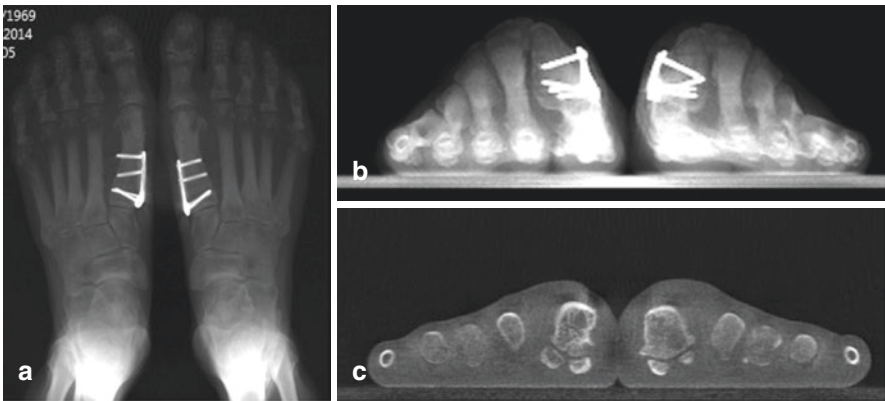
(a–c) Assessment of bilateral hallux valgus correction. (a) shows a virtual dorsoplantar weight-bearing radiograph, generated from the WBCT-3D-dataset. (b) shows a generated Metatarsal-Skyline view, and (c) a paracoronal reformation. The rotation of the first metatarsal head and its position in relation to the sesamoids is better visible on the paracoronal reformation (c) than on the metatarsal-skyline view (b) which represents the former visualization with conventional weight-bearing radiographs
